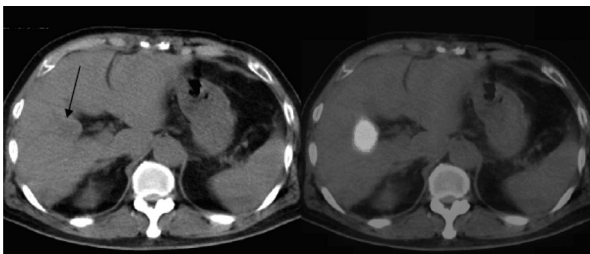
(A). The 2nd time liver metastasis. Left, abdominal CT showed S5 metastases (arrow), which was compatible with the right-side lesion on PET/CT.
